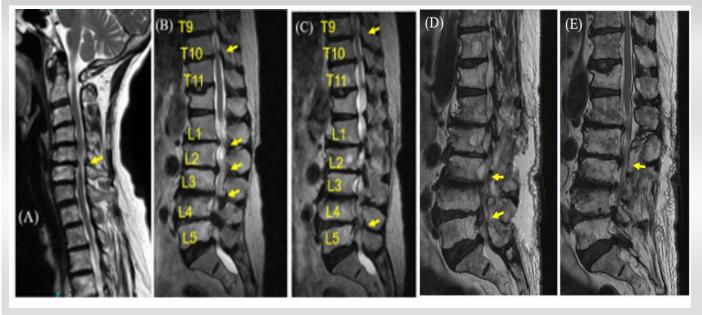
Magnetic resonance imaging (MRI) of Case 2 (a-c) Pre-operative images show multiple levels of spinal stenosis in C5/6, T9/10, T10/11, L1/2, L2/3, L3/4, L4/5, L5/S. (d and e) Post-operative MRI image of Case 2. There was a massive hematoma in the space after nerve decompression, which was compressing the spinal canal. Therefore, surgical removal of the hematoma was performed.
